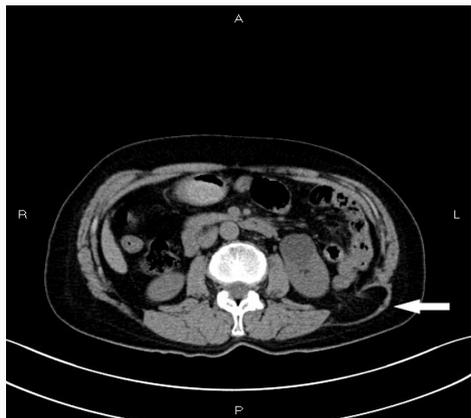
Axial CT image shows the protrusion of the extraperitoneal adipose tissue through a defect in the posterolateral abdominal wall.
